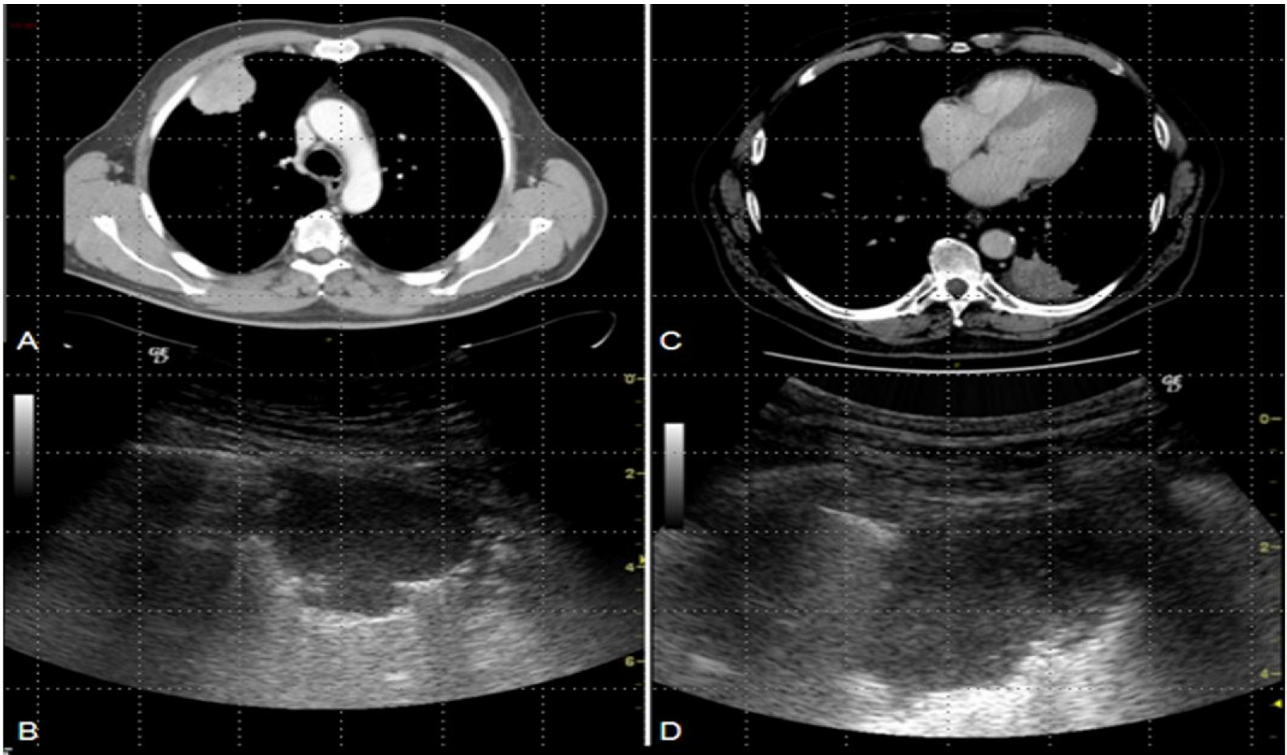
Peripheral lung tumor image. Fig. 2A and Fig. 2C shows a CT scan with signs of suspect pleural infiltration. Fig. 2B and Fig. 2D shows Ultrasound appearance.
